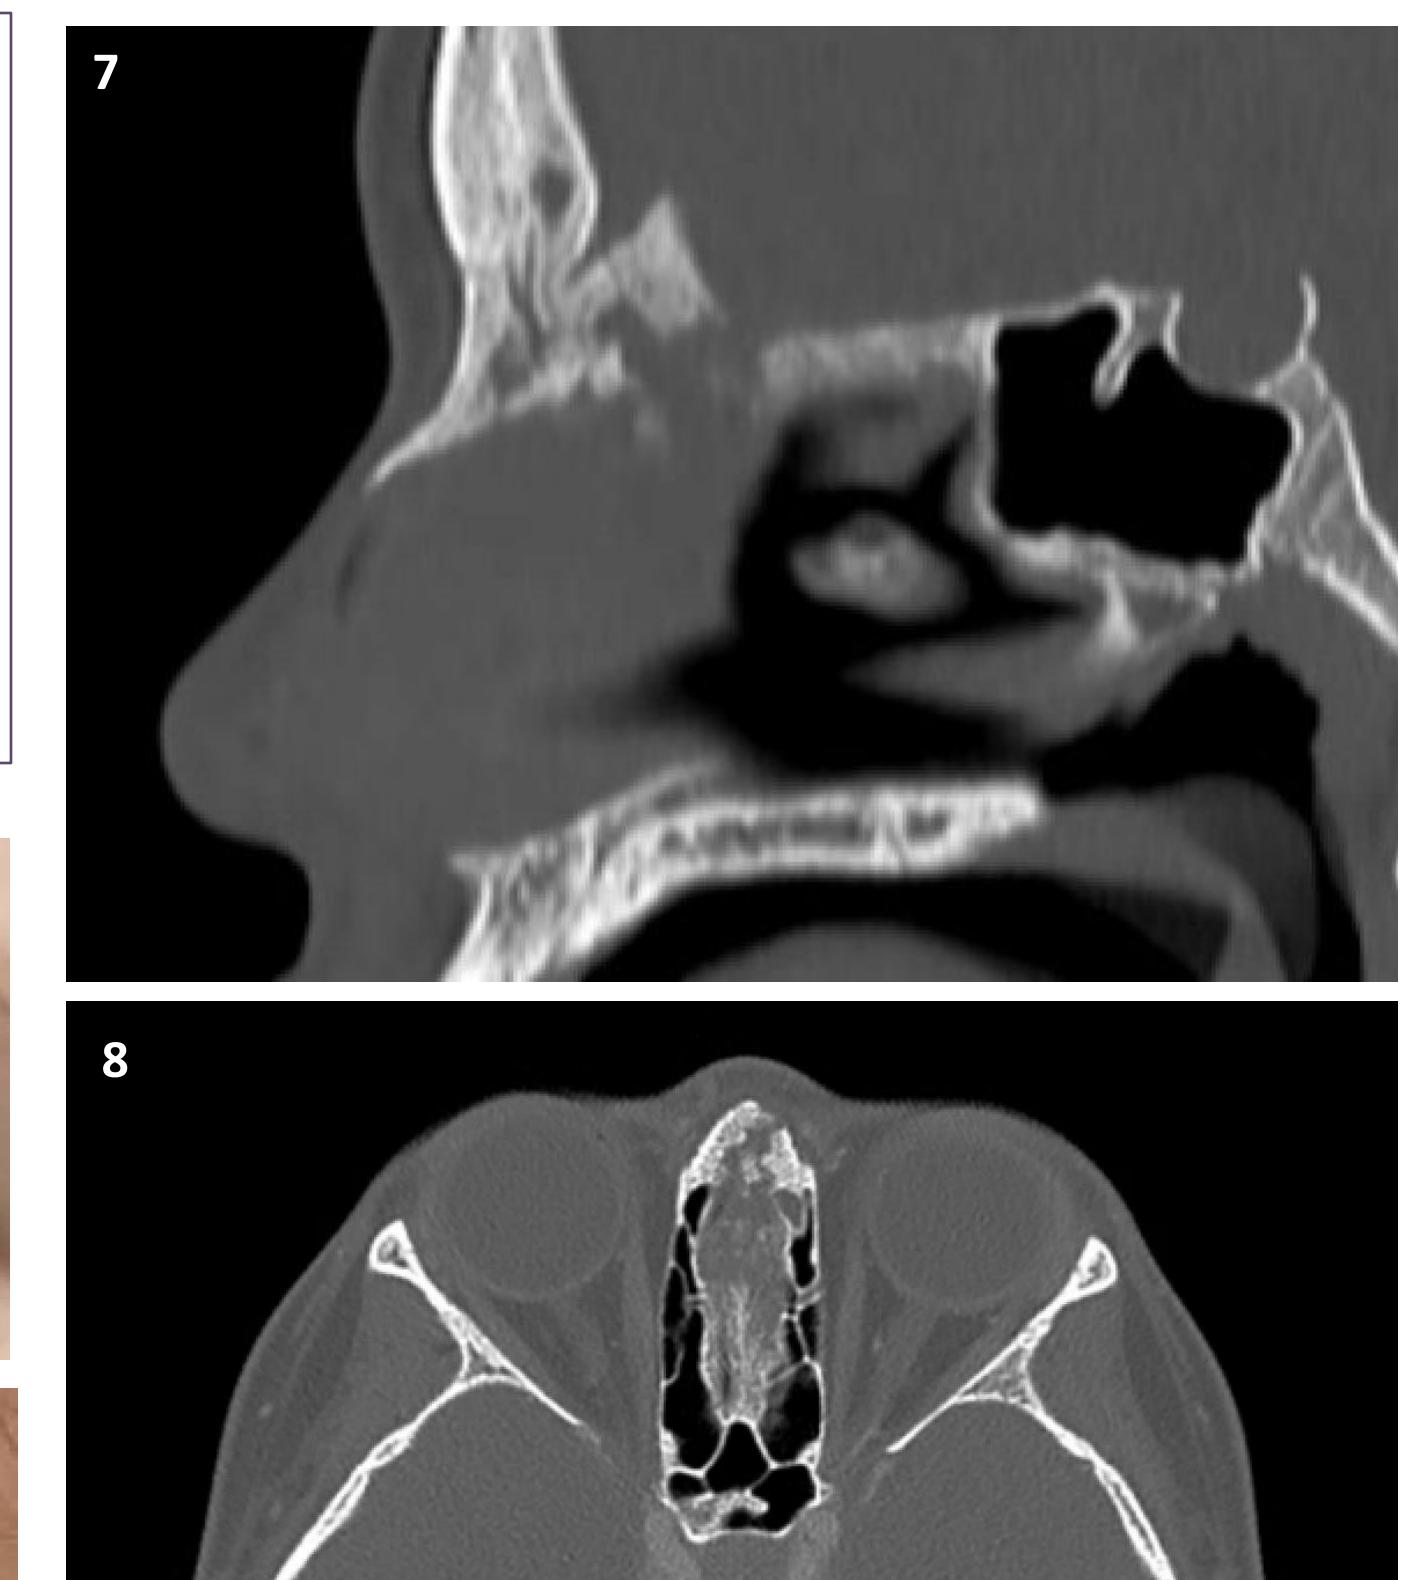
4-month follow-up CT Maxillofacial
